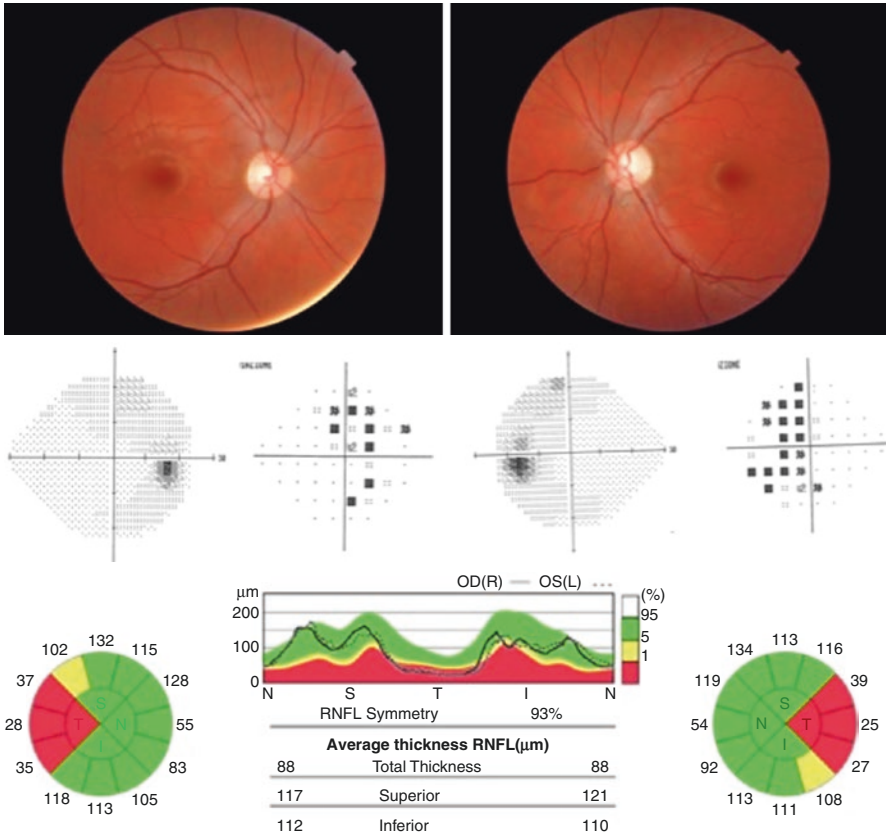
SPG7. 24 year female carrying compound heterozygous mutations- c.524T>C (p.LI75P) + c1968_69 ins A (p.165NfsX22) in the SPG7 gene. Visual acuity is 20/32 (0.63). Fundus oculi reveals bilateral temporal optic nerve pallor. Visual fields showed small central scotoma bilaterally and OCT demonstrated temporal RNFL thinning bilaterally. Brain MRI, somatosensory and motor evoked potentials were normal. Neurological examination did not show the presence of spastic paraparesis
